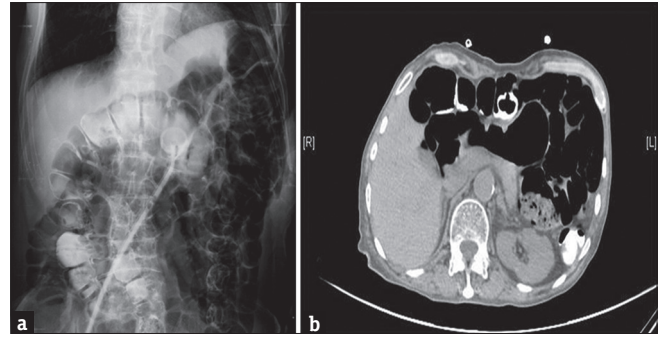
(a) X ray showing PEG tube migrated into bowel. (b) Axial section of CT showing internal bumper of percutaneous endoscopic gastrostomy tube
